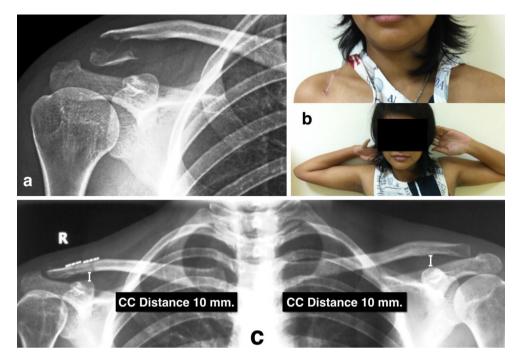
a A 22-year-old female with an acute unstable distal clavicle fracture. b The patient's clinical status and radiograph at follow-up 20 weeks after surgery
